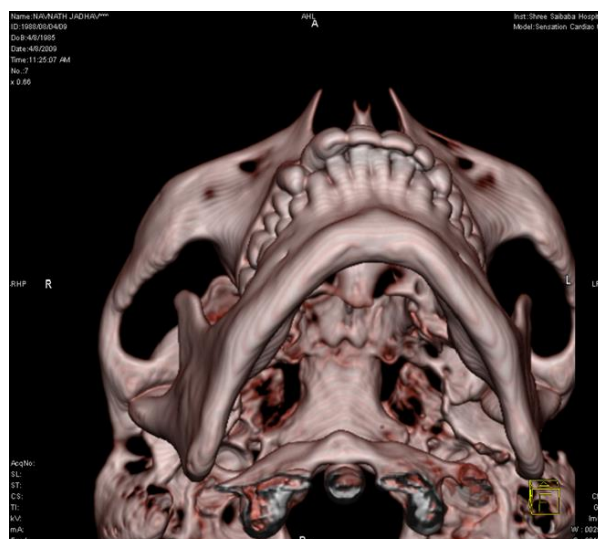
Spiral computed tomography images.
